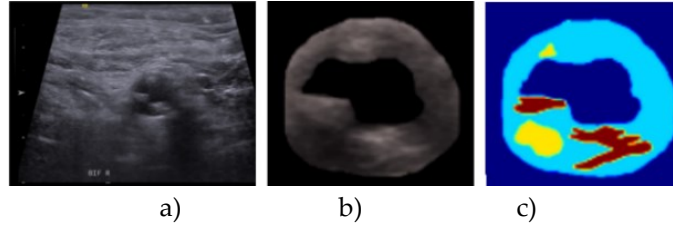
Original ultrasound image (a), extracted carotid artery (b), annotated plaque (c).
